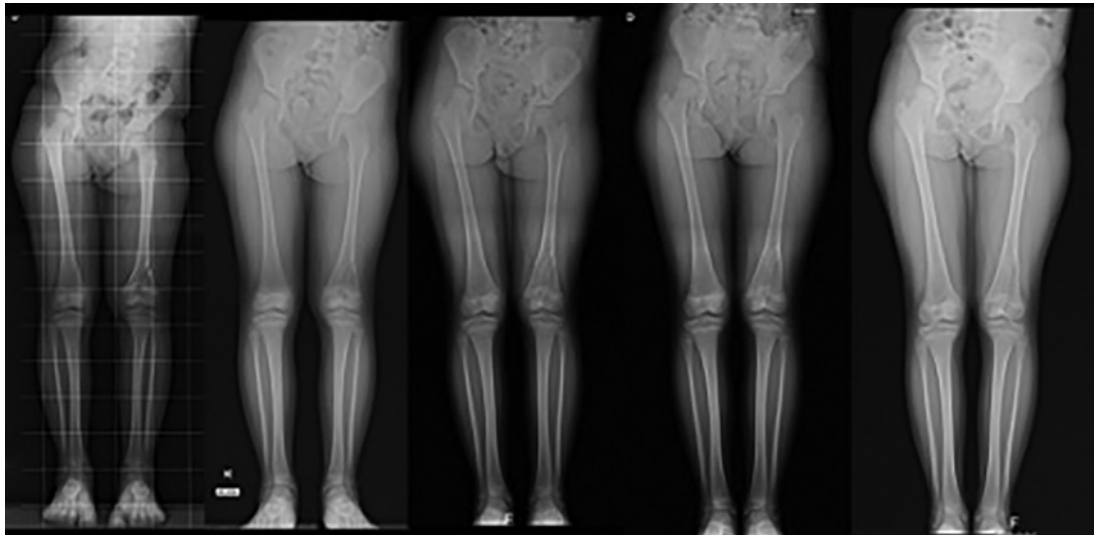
Long X-ray follow-up at 3, 9, 15, 24, and 30 months (from left to right).
